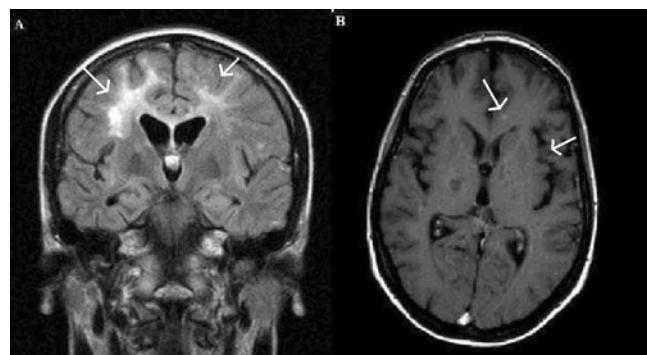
Patient #1, panel A) Coronal FLAIR (fluid attenuated inversion recovery) sequences showed diffuse signal hyperintensity of the subcortical and deep lobar white matter, more pronounced in the right emisphere (arrows). Panel B) Small foci of contrast enhancement in the white matter (arrows) were showed on T1 weighted image post contrast injection at T1.
